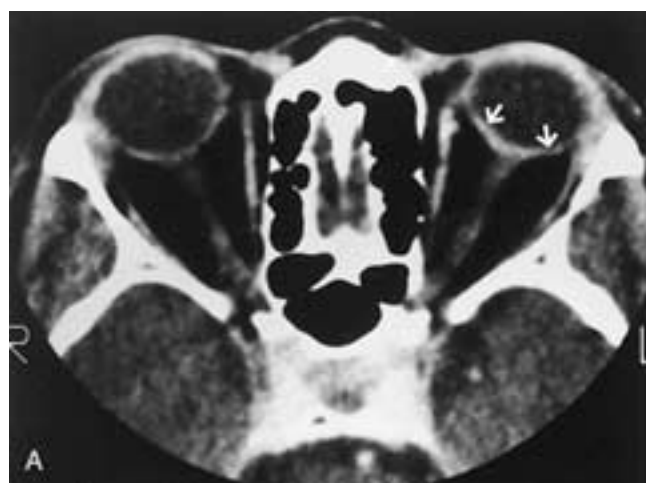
Retinal detachment. A, Axial CT scan shows a dependent image of increased density (*arrows*) of the left eye caused by retinal detachment. B, Axial PW MR image shows a dependent hyperintense image (*arrows*) of the right vitreous chamber caused by a subretinal exudate.
